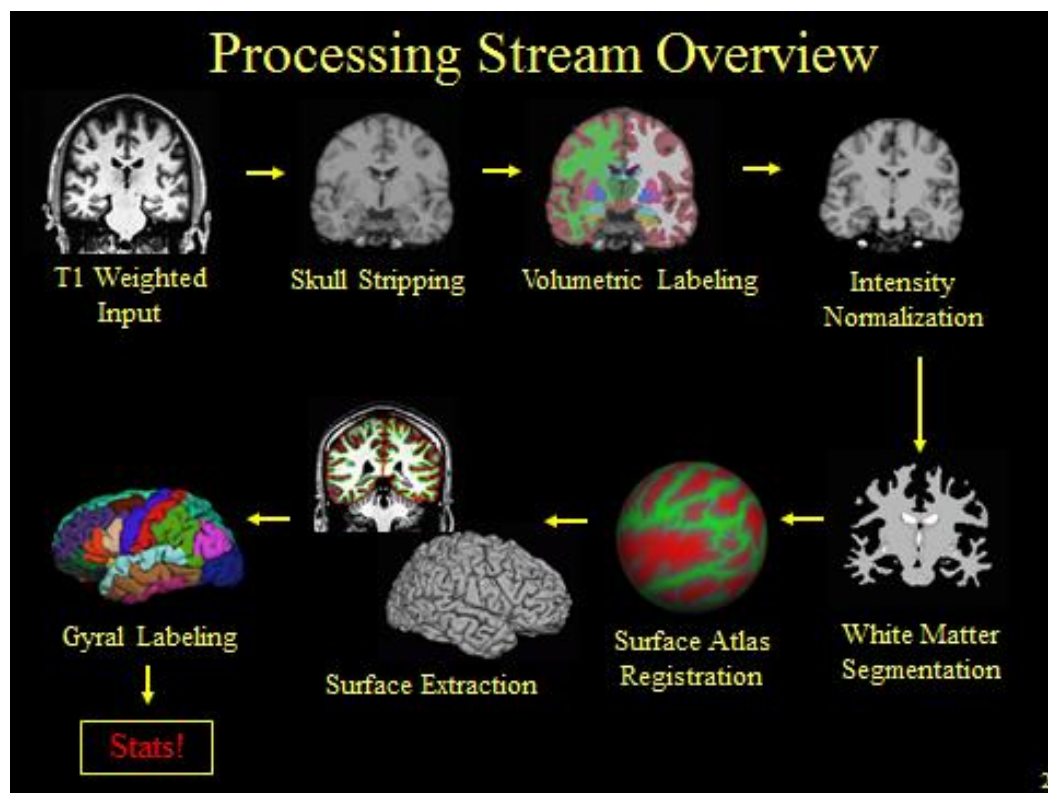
Recon-all processing stream steps for Freesurfer MRI analysis (Kaufman 2016)
